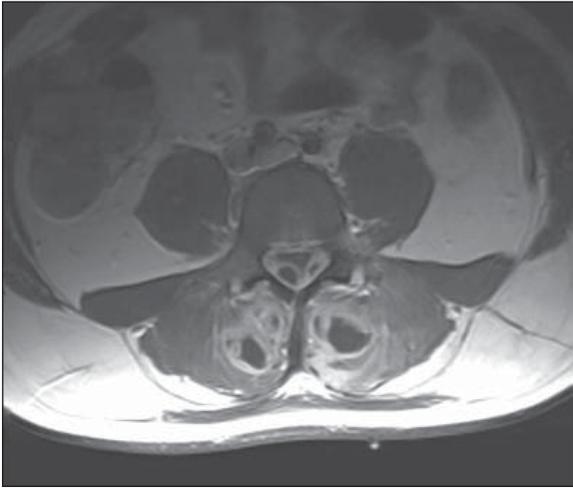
T1-weighted MR image after gadolinium: the bilateral patchy alteration of the paravertebral muscles and the posterior epidural space involvement are evident on the axial scan.
